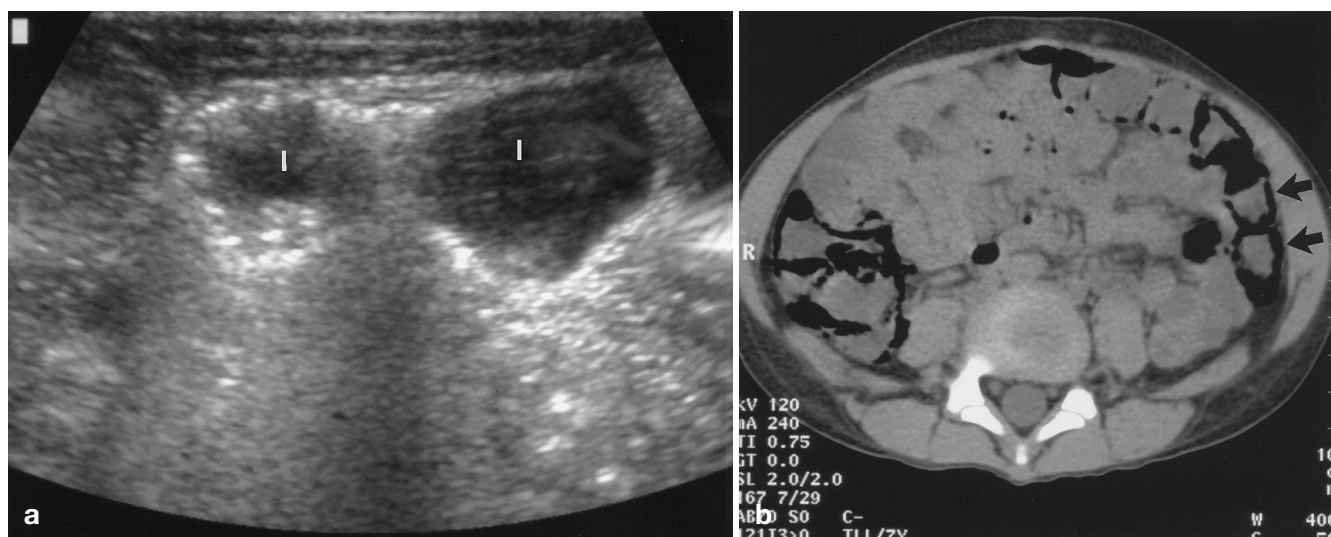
a US demonstrates course echogenic foci within the walls of two adjacent loops of bowel. The “circle sign” is seen (*l* loop). b CT scan confirms extensive pneumatosis, some in a circular pattern (*arrows*) within the bowel wall, as was seen on US and the radiograph
